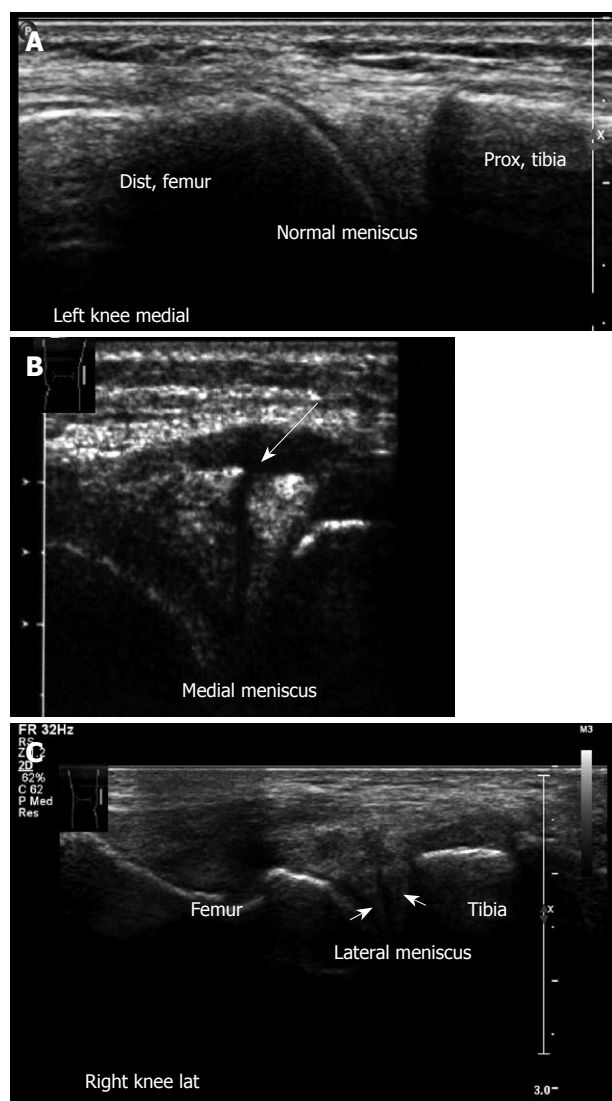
Meniscal lesions. A: Left knee medial aspect, longitudinal sonogram. Medial meniscus anterior horn. Note the triangle-shaped hyperechoic structure of the normal medial meniscus; B: Medial meniscus lesion. Note the cleft and irregularity of the torn meniscus. This young football player suffered an acute twisting injury. Clinically he had pain with mild swelling on the medial aspect, there was a joint effusion with medial line tenderness. Mac-Murray and Apley tests were positive over the medial meniscus; Right knee lateral meniscus lesion. Note the irregularity of the torn lateral meniscus.
